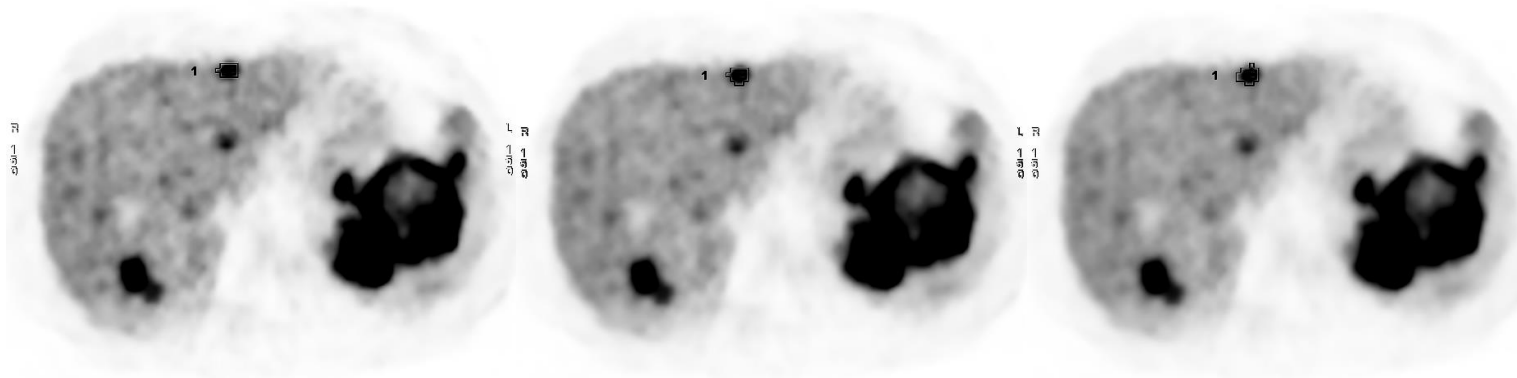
2 1-layer of the PET/CT image series obtained for the patient with neuroendocrinal tumour with marked lesion of pathological uptake. From left side: images obtained with the VP FX Q. Clear reconstruction technique with Beta in range 350-550, step 100.
